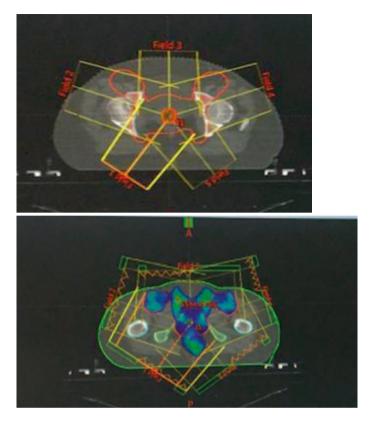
(a and b) Intensity-modulated radiation therapy with multiple modulated fields to a CT scan localized target
